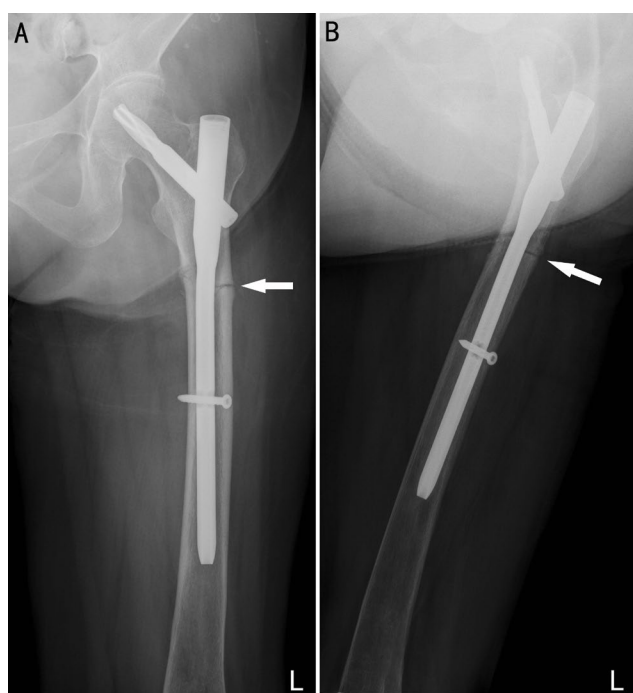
Radiographs (A,B) of left femur at 3-month follow-up showed few callus formation in the region of the subtrochanteric fracture (arrow).
